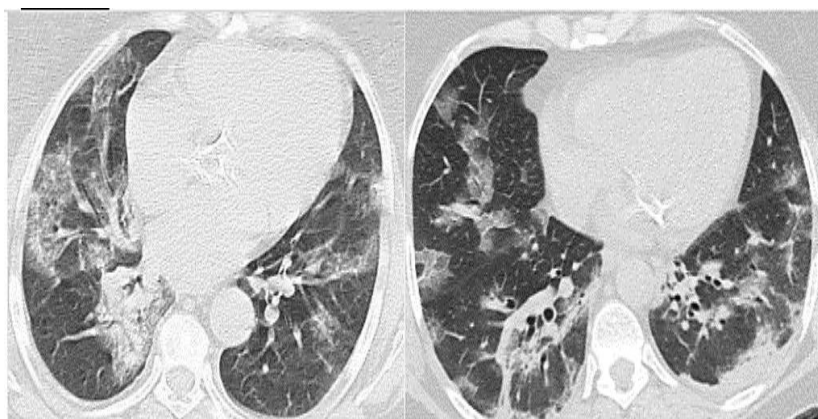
Example of the image in the SARS-CoV-2 CT dataset.
